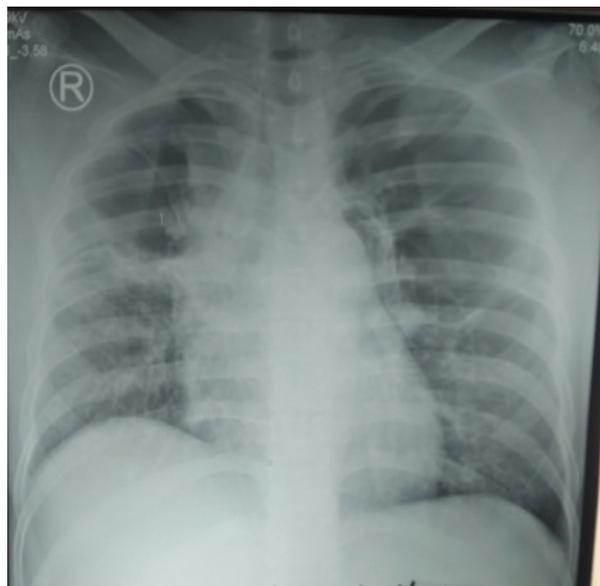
Chest X-ray revealed the fibrotic process and multiple bullae in right and left apex hemithorax.
